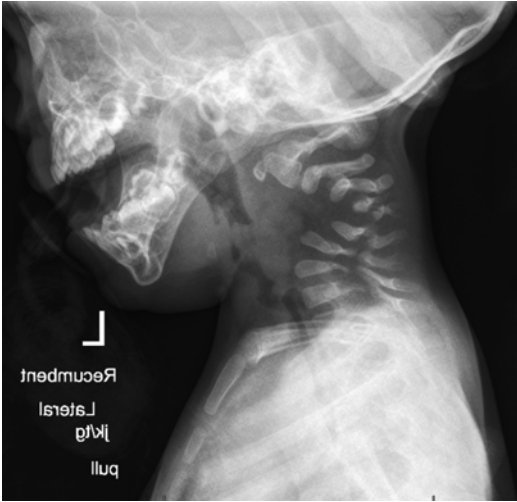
Screening lateral cervical X-ray in Larsen showed mid-cervical kyphosis that has a progressive natural history
